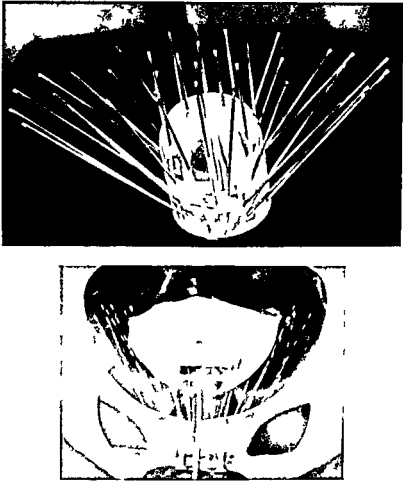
9 Co⁶⁰ implantation of cervix uteri and parametrium with rigid needles (Upper) A photograph of an applicator used in the treatment of carcinoma of the cervix with Co⁶⁰ The lucite guide cylinder fits into the vagina and the needles are inserted one by one through predrilled holes until the pattern is complete A block of tissue approximately 4 X 7 X 12 cm is treated uniformly to a dosage of 7 000 r in 1 week (Lower) Radiographic image showing the actual placement of the needles in the pelvis in a typical case as well as the positions of the individual Co⁶⁰ sources in the needles
